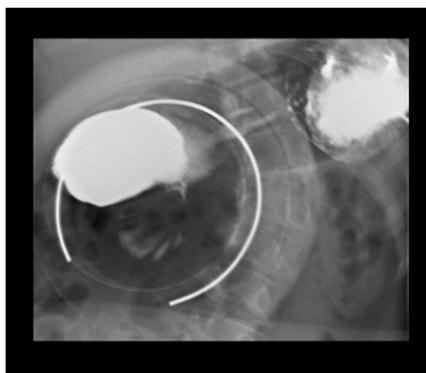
Contrast-enhanced radiographs of the upper GI tract show a dilated duodenum with minimal contrast in the distal intestine, which is suggestive of a duodenal stricture.
